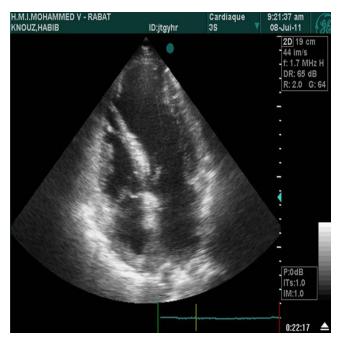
Echocardiographic aspect of apical muscular VSR
